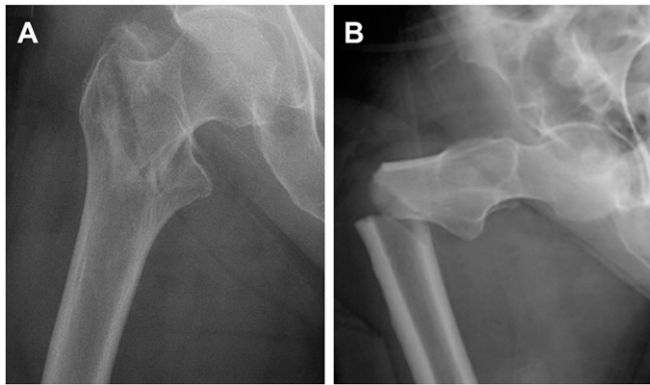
Radiographs showing morphology of a typical intertrochanteric fragility fracture (A), compared with an AFF (B). Whereas the typical fracture has a tortuous crack path indicative of interaction with microstructural features that act as toughening mechanisms, the atypical fracture has a transverse morphology indicative of a brittle fracture process.
